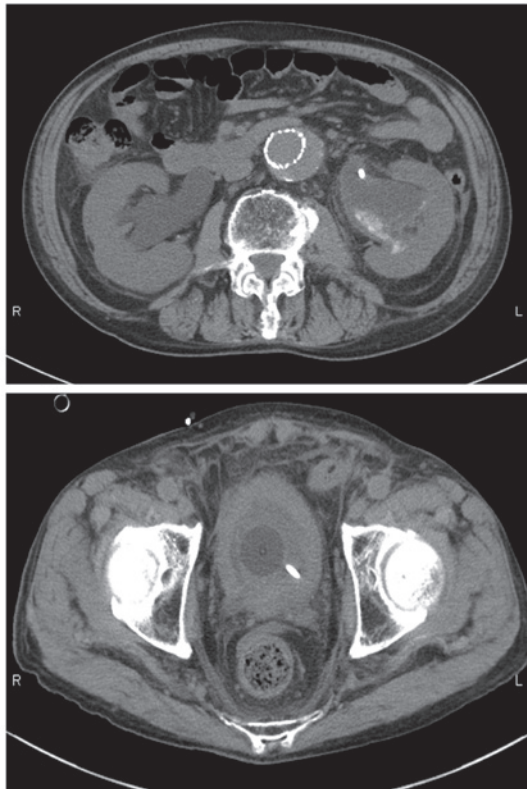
Abdominal computed tomography scan prior to bilateral percutaneous nephrostomies revealed bilateral hydronephroses (upper) and bladder wall thickness with coagula tamponade (lower).
